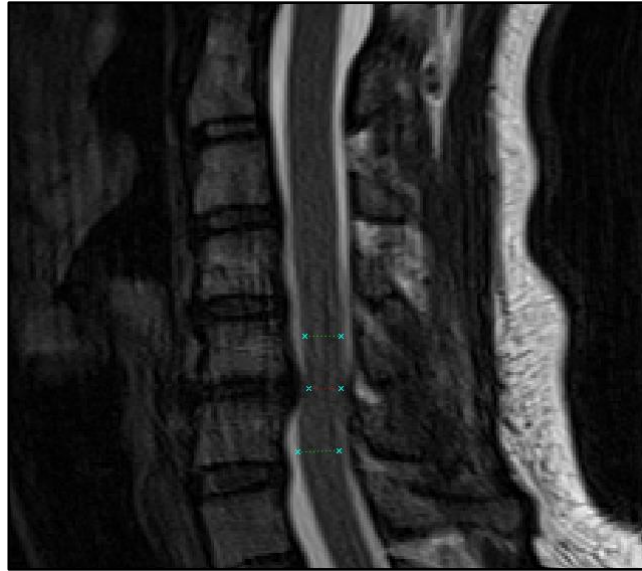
Spinal cord compression landmarks identified on mid-sagittal MRI. Sagittal cord diameter at the superior and inferior uninjured levels is measured to calculate cord compression as a percentage of the normal cord diameter.
